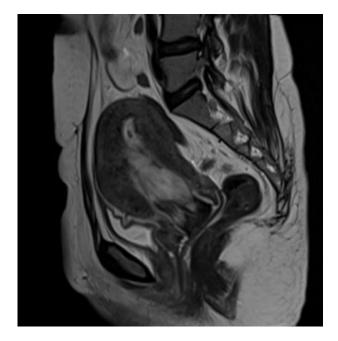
Sagittal T2w MRI showing heterogeneously hyperintense pedunculated polypoidal mass lesion of $9 \times 3 \times 3.9$ cm arising from upper anterior uterine wall.
